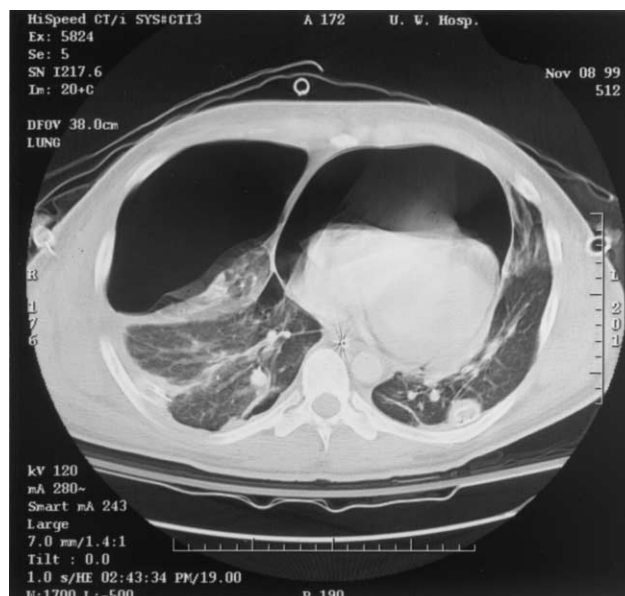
Computed tomographic (CT) scan demonstrating pneumopericardium with the heart displayed posteriorly by air.
